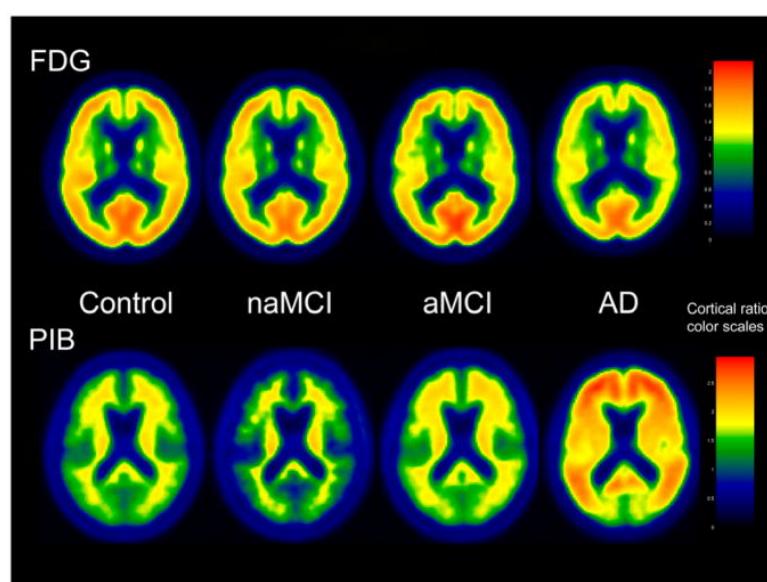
Média de captação de FDG e PIB em indivíduos com diferentes progressões da DA e com naMCI. Regiões com maior captação em vermelho e amarelo. naMCI: *non-amnestic mild cognitive impairment*; aMCI: *amnestic mild cognitive impairment*; AD: *Alzheimer's disease*. Fonte: (MOSCONI et al., 2008b).
